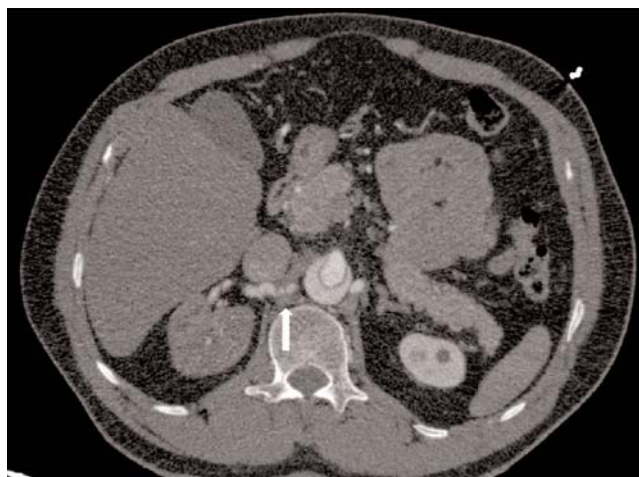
Axial MIP CT image shows the entrapment and critical stenosis of right renal artery (arrow). Note the ostial compression of left renal artery with left diaphragmatic crus and the nonenhancing upper pole of right kidney.
